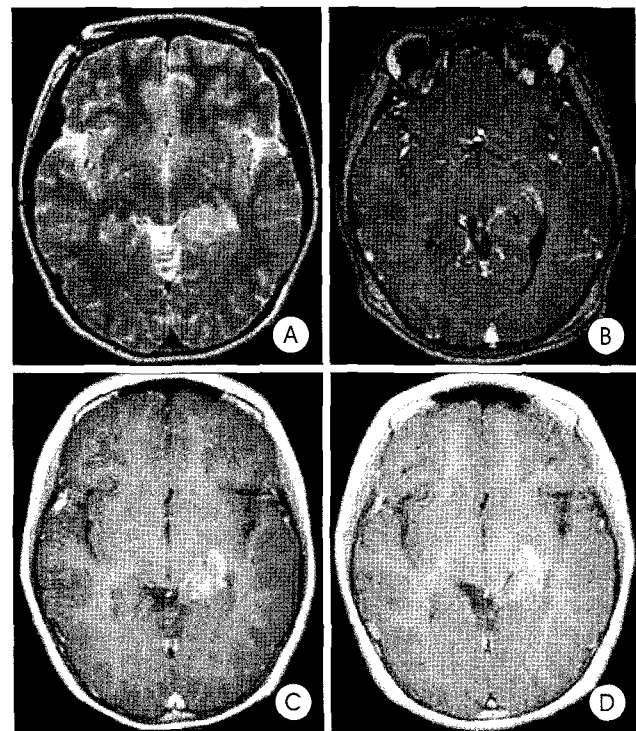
A : T2-weighted magnetic resonance MR imaging showing a non-enhancing lesion in the left mesial temporal area. B : T1-weighted enhanced MR image at the time of Gamma Knife radiosurgery(GKS) showing a signal defect due to previous stereotactic biopsy. C : Tumor is enhanced 10 months after GKS. D : No significant change on MR image 22 months after GKS.
